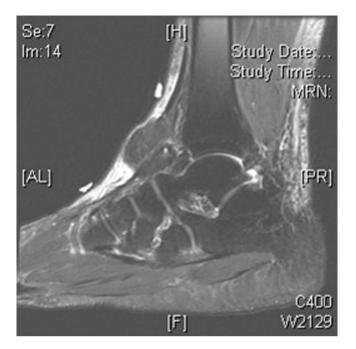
T2 weighted sagittal MRI image of an angiolipoma of the distal ankle and forefoot
